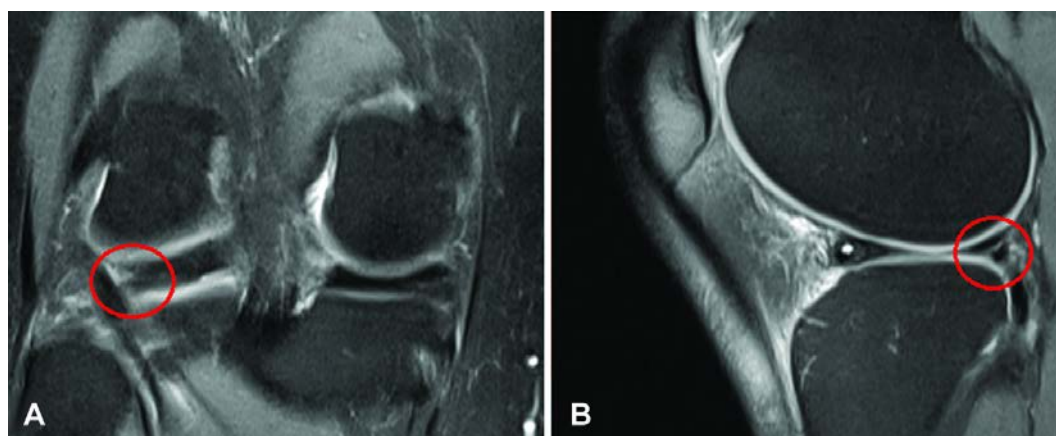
MRI scans of the right knee in a 29-year-old patient K. showing: A – high MRI signal at marginal portions of the posterior horn of the lateral meniscus susceptible of a tear on coronal plane; B – horizontal area seen in the posterior horn of the lateral meniscus (Stoller grade III) on sagittal plane
